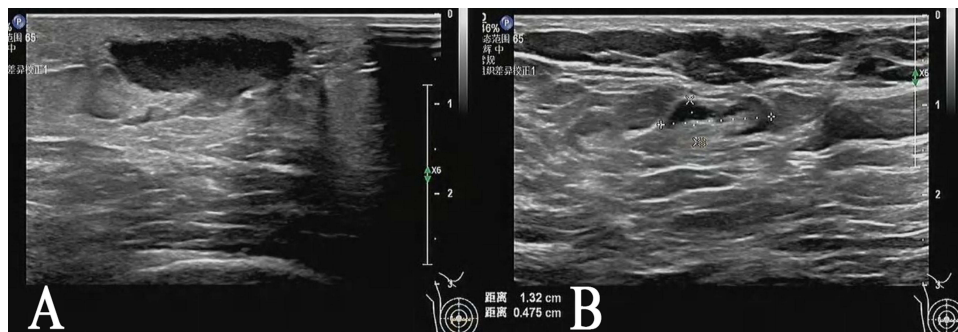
Ultrasound examination detected an ill-defined, irregular hypoechoic lesion, measuring 2.2×0.9 cm with internal vascular signals, in the subareolar region of the right breast (A). Right axillary lymphadenopathy was identified on the ultrasound images (B).
